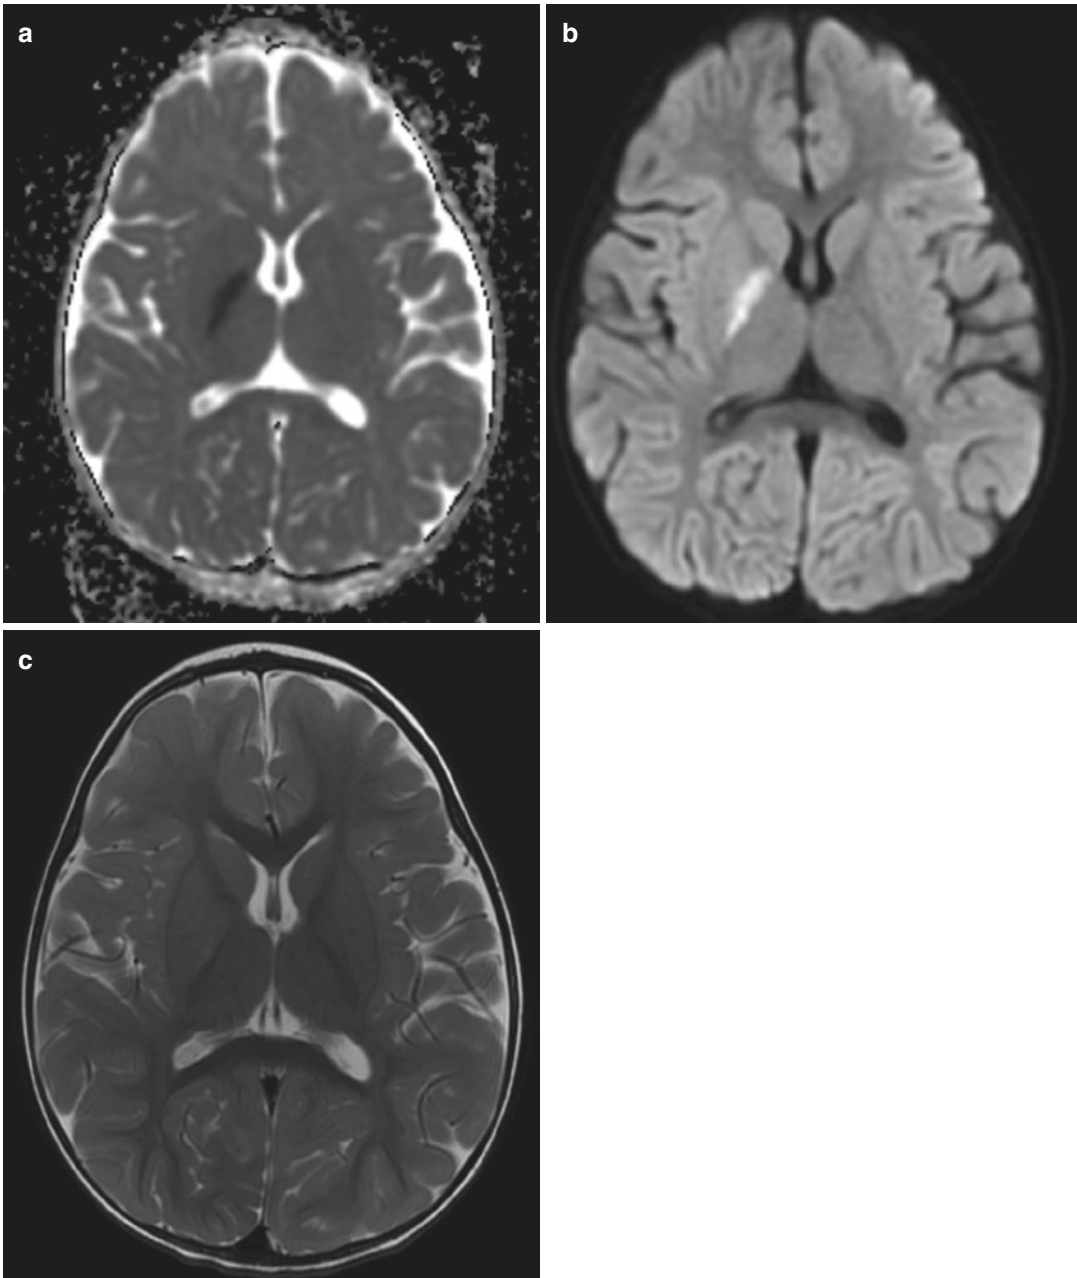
Brain infarction involving the L. MCA territory from the complete occlusion of Lt. ICA in a 5-year-old girl with mycoplasma pneumonia. Diffusion-weighted MRI (a), ADC map (b), and T2-weighted axial images (c)
